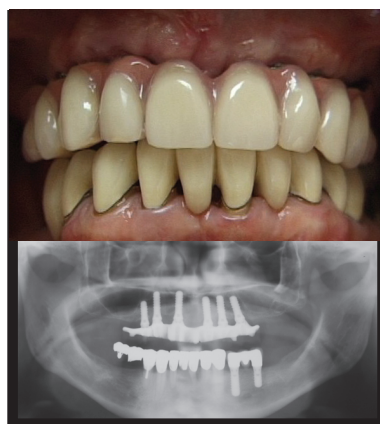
Clinical photograph and panoramic radiograph of a patient at the 5 year follow-up
